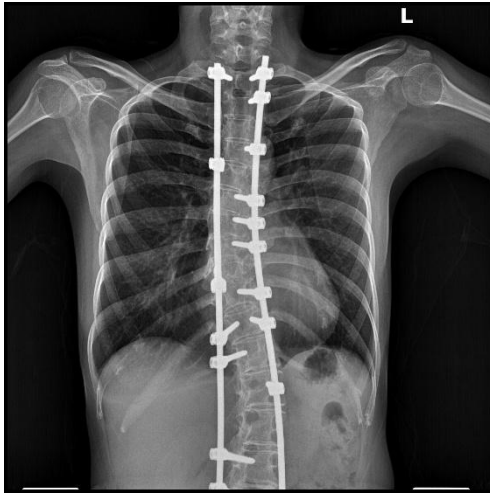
Chest x-ray showing spinal fixation
